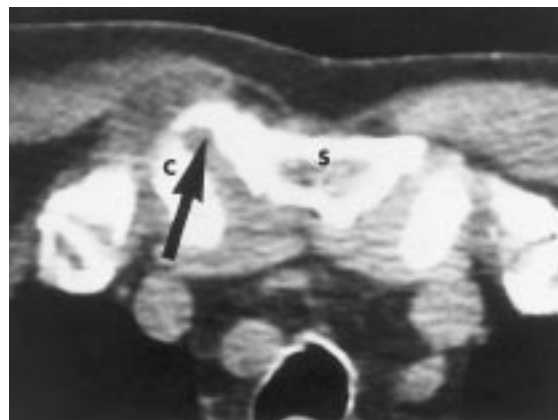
CT scan of a 63-year-old right hand-dominant man who worked more than 45 years as a landscaper. Image demonstrates a hyper-trophic, degenerative right sternoclavicular joint consistent with osteoarthritis (arrow). C = medial clavicle; S = sternum.
